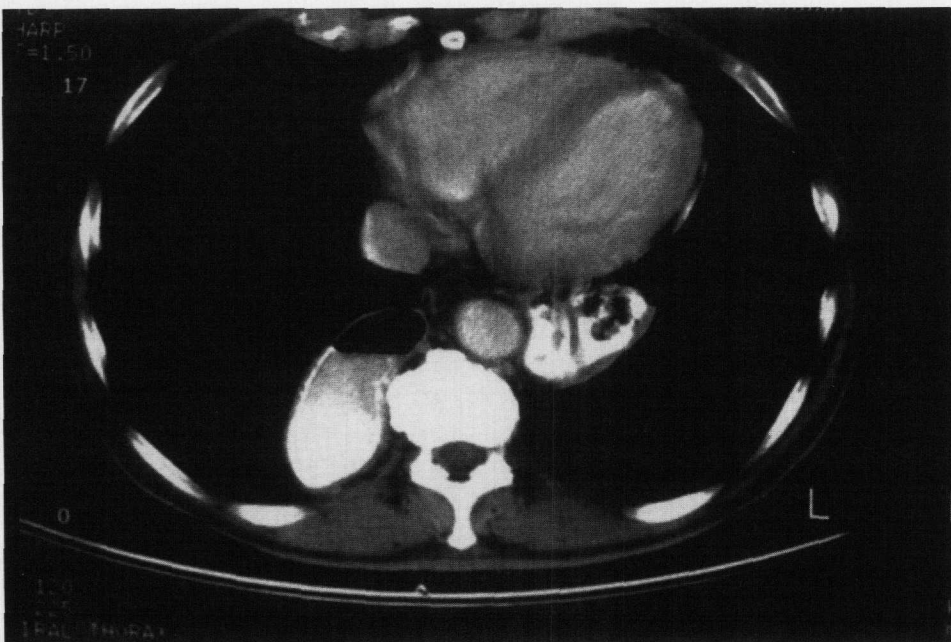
CT scan of chest and abdomen confirming herniation of colon into the chest.
